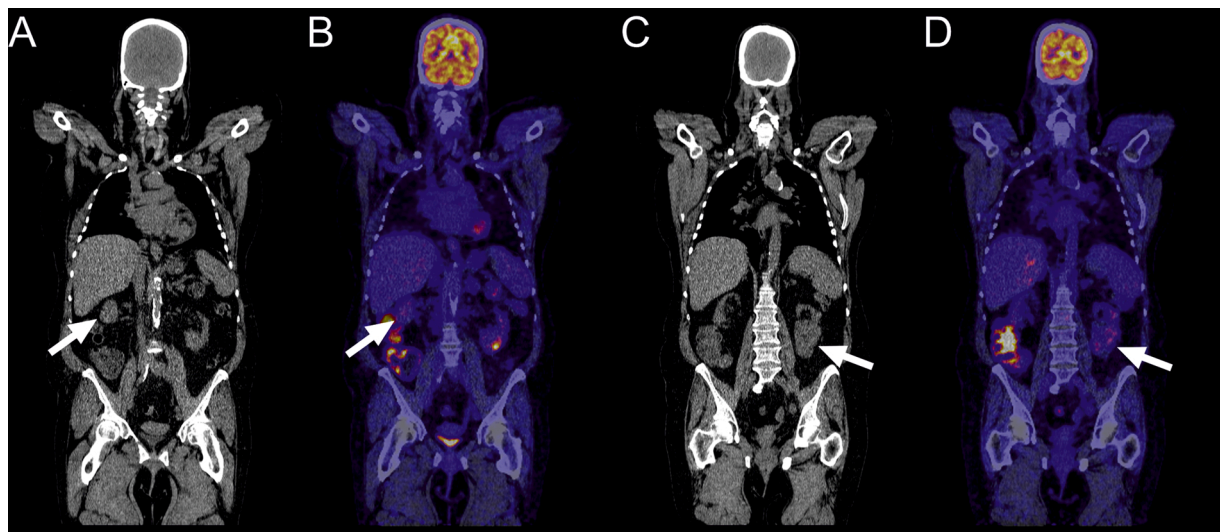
A 59-year-old woman with fever of unknown origin. Low-dose FDG-PET/CT was performed to search for an infectious focus. Coronal low-dose CT (A, C) with corresponding coronal fused FDG-PET/CT (B, D) slices at two different levels are demonstrated. No infectious focus was found at FDG-PET/CT. Although both kidneys contained masses with low FDG avidity (A-D, arrows), they were not described in the original report. These masses proved to be clear cell renal cell carcinomas on follow-up. This perceptual error was corrected with an addendum 14 days after authorization of the original report.
